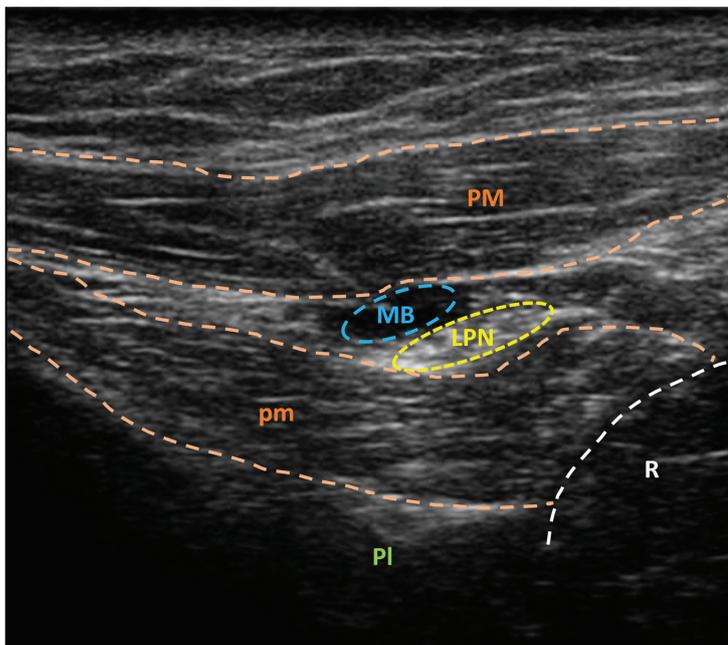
Ultrasonographic visualization of lateral pectoral nerve (yellow circle) after methylene blue injection (blue circle). LPN: lateral pectoral nerve; MB: methylene blue; PI: pleura; PM: pectoralis major muscle; pm: pectoralis minor muscle; R: rib. A sonographic unit (Sonoscape X3, Sonoscape Europe s.r.l., Rome, Italy), coupled with a linear multifrequency probe (5–14 MHz, L741, Sonoscape Europe s.r.l., Rome, Italy), was used for ultrasonographic guidance.
